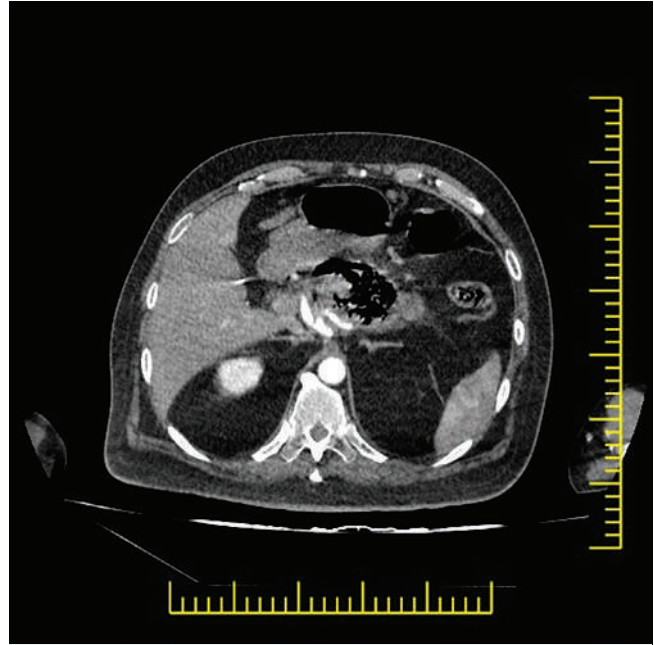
CT angiography. CT angiography showed irregularity at the splenic artery root.
